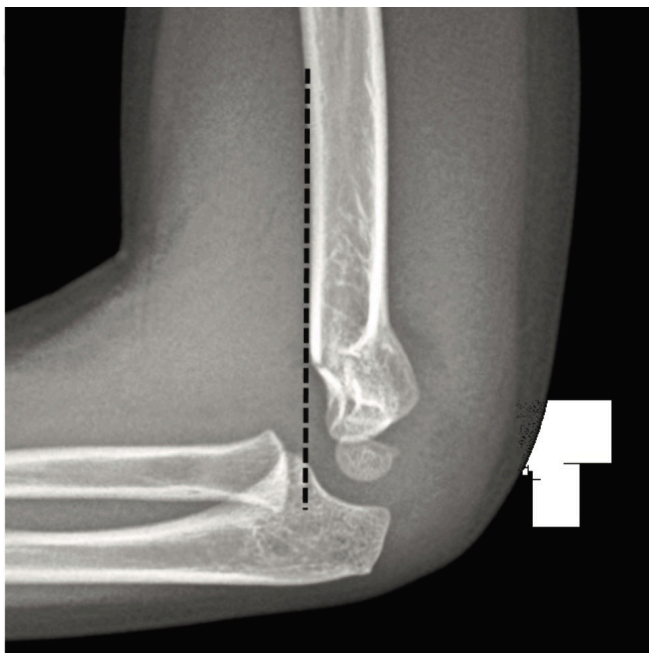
A lateral elbow X-ray showing the anterior humeral line in a humeral supracondylar fracture. (Credit: DeFroda S, Hansen H, Cruz JR A. Radiographic evaluation of common pediatric elbow injuries. *Orthop Rev.* 2017;9(1):7030.
